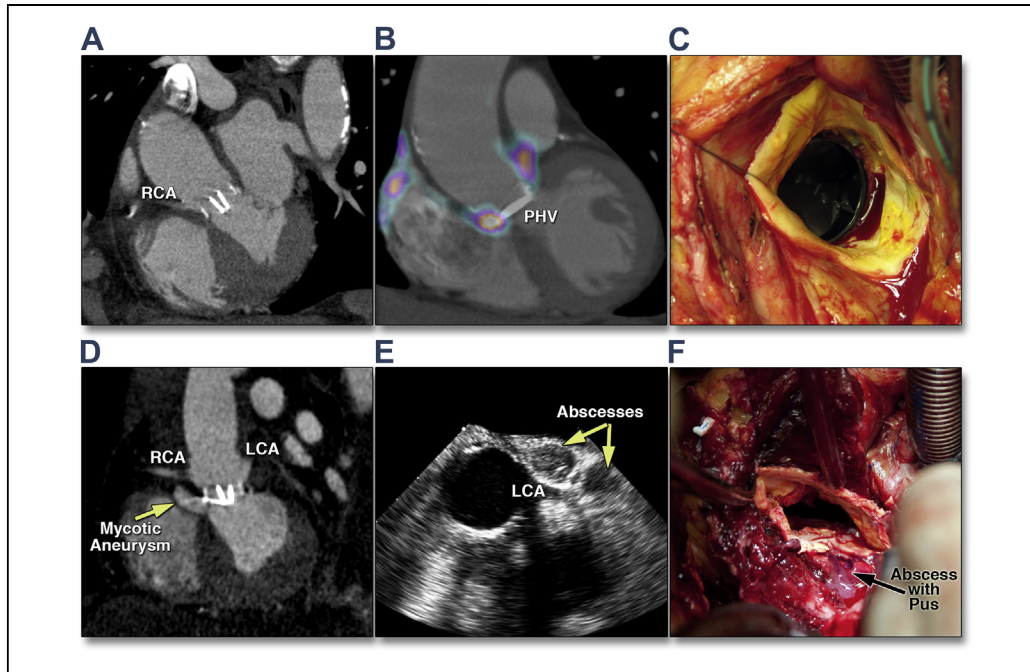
Periannular Extension of PHV Endocarditis Initially Missed by TTE/TEE/CTA but Correctly Detected by FDG-PET
